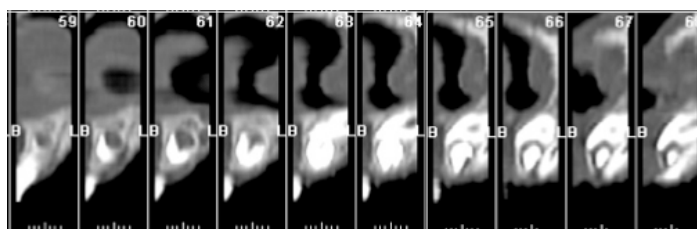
Anterior maxilla cross-sectional images resulting of Dental CT evaluation. These images allow visualization of both impacted teeth and a cyst formation.
